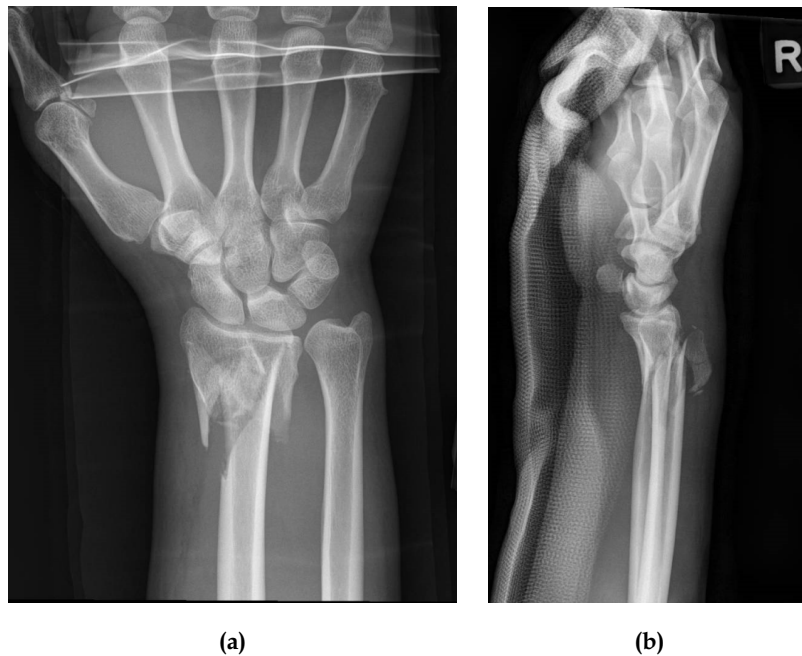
(a) Anterior view of radiograph of the right distal radius fracture and (b) Lateral view of radiograph of the right distal radius fracture.
